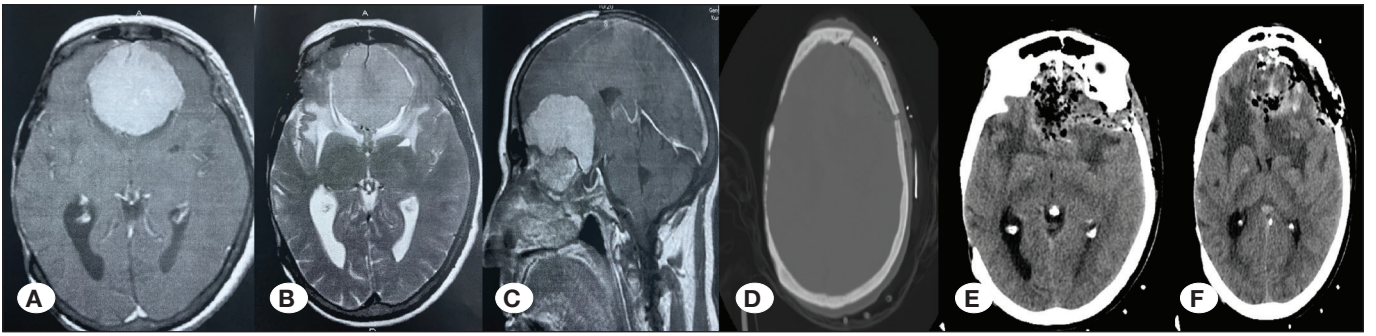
Preoperative cranial MRI showing a large olfactory groove meningioma (A: T1-weighted axial image with contrast enhancement, B: T2-weighted axial image, C: T1-weighted sagittal image with contrast enhancement). D) Craniotomy borders are visible on axial computed tomography axial CT scans. E-F) Postoperative CT confirming total excision of the mass lesion.
